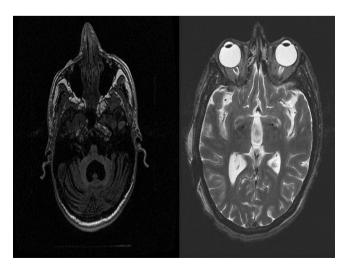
T2-weighted axial postoperative MRI scans, verifying appropriate lead positioning, Patient 1 (Left), Patient 2 (Right).
